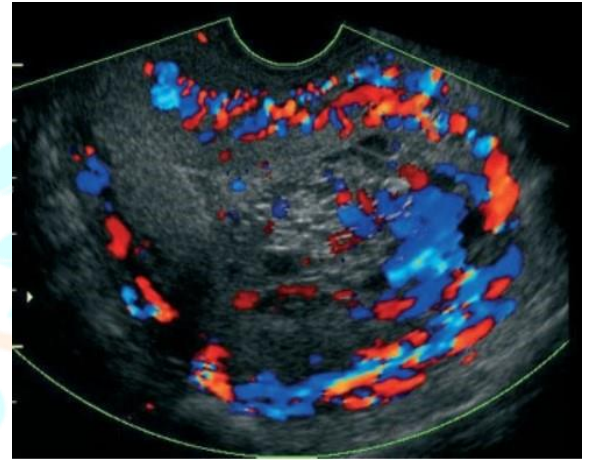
"b" Increased colour flow on doppler
